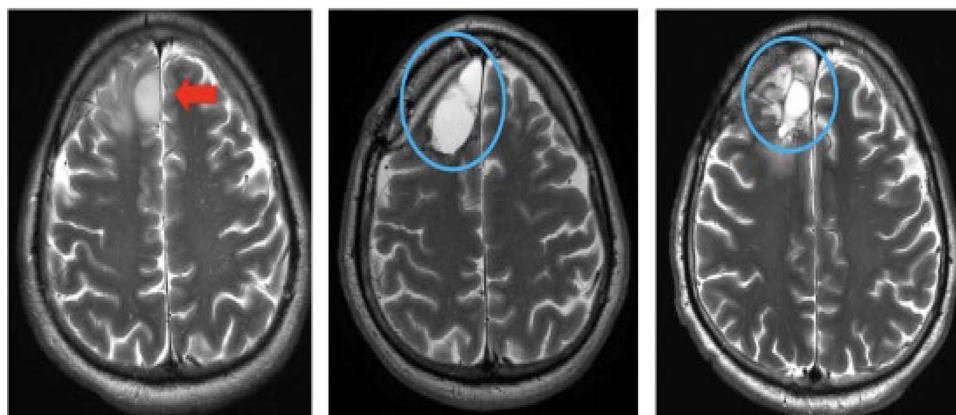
Serial magnetic resonance images of the brain for case 2 (T2 images). *Left:* Right frontal mass at the time of diagnosis (red arrow). *Middle and right:* MRI brain at 1 and 23 months after tumor resection, respectively (blue circle shows postsurgical change without disease recurrence). The patient was progression-free at 52+ months.
